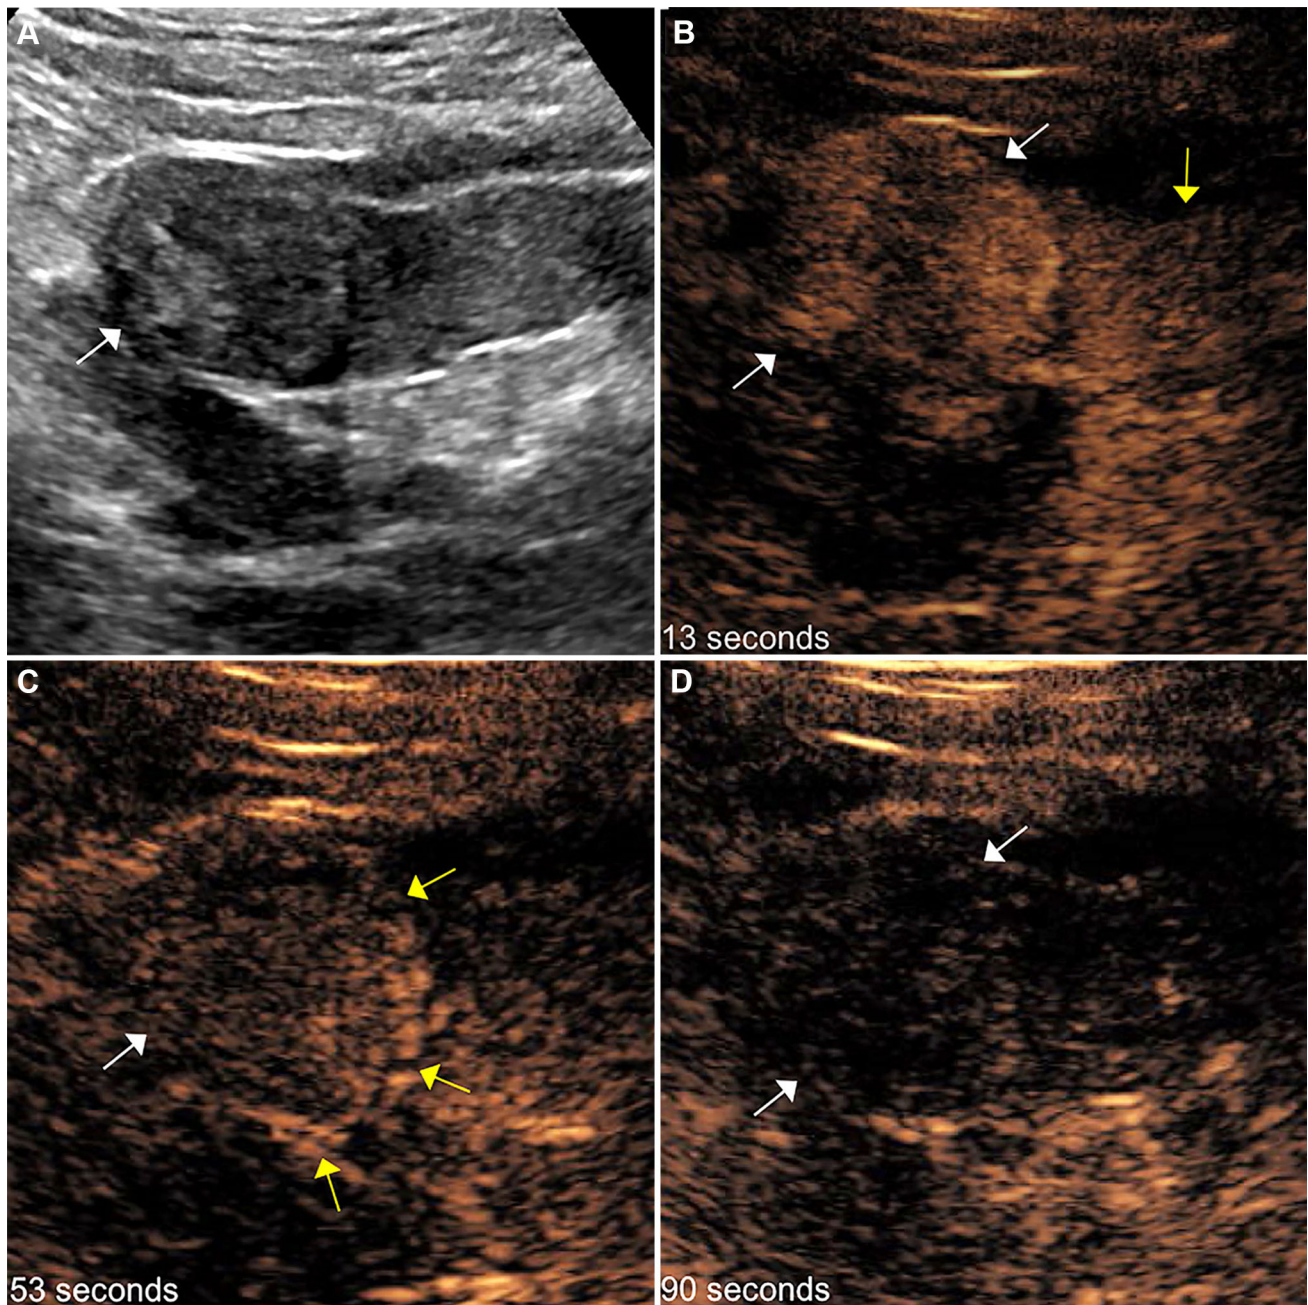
A 51-year-old male with solid left renal mass. A Grayscale sonographic image of the left kidney demonstrates an oval isoechoic mass at the upper pole (*arrow*). B CEUS in the arterial phase (13 s) shows avid arterial enhancement of this lesion (*white arrows*) greater than the adjacent renal cortex (*yellow arrow*). C In the venous phase
